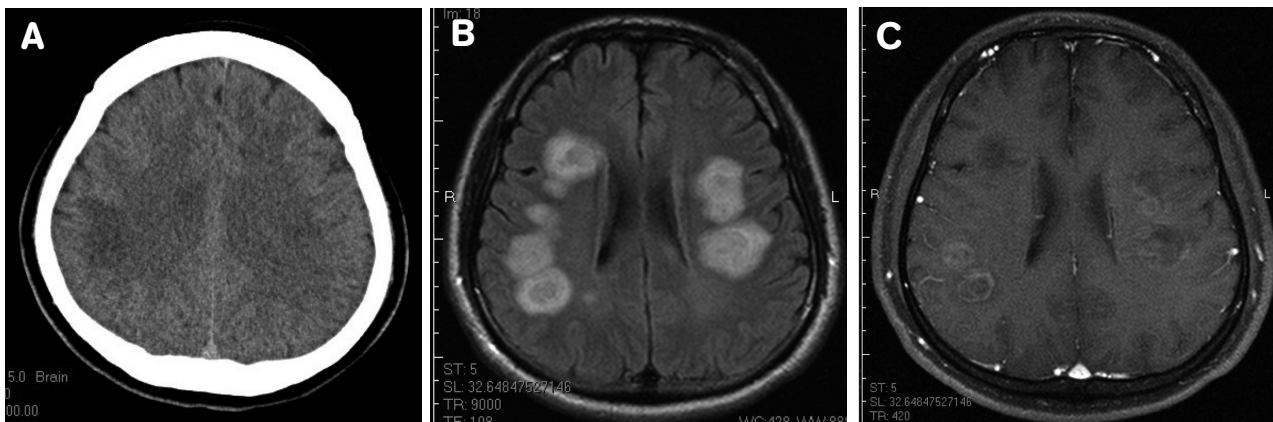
(A)CT: ill-b hypodense matter. (B)MRI: attenuated recovery (FLAIR) image shows oval the matter. (C)MRI: T1 shows hypoattenuated.
